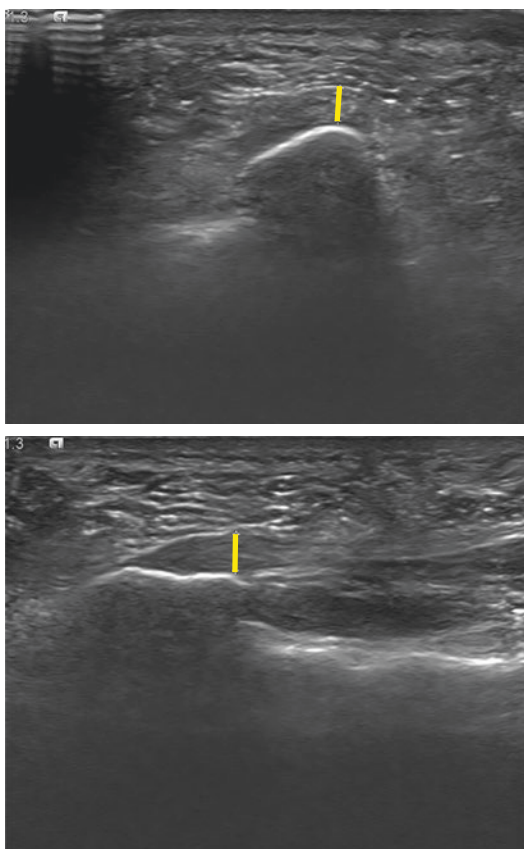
Ultrasonography of the plantar fascia depicting plantar fasciitis
